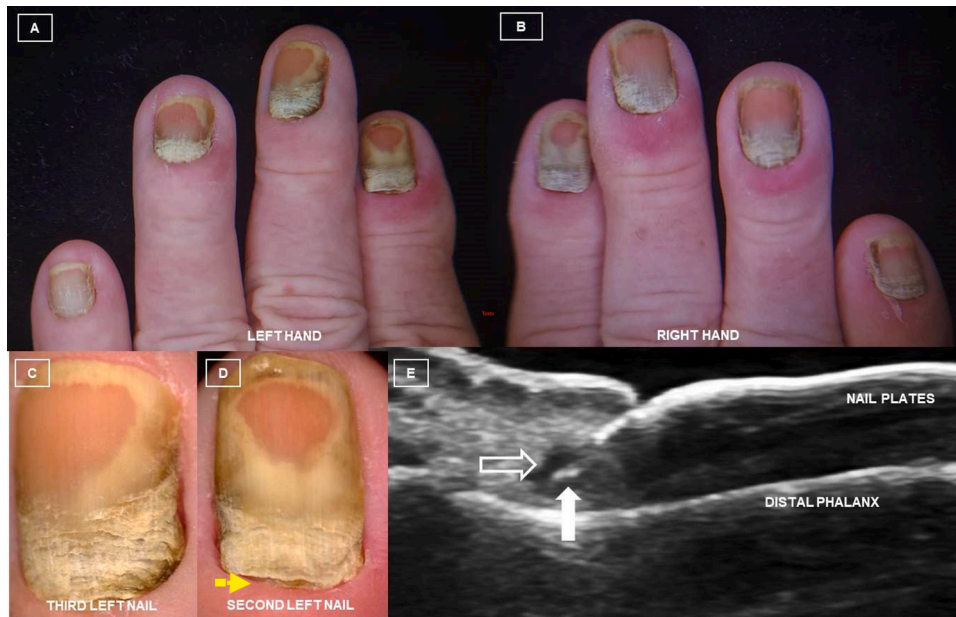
Parts A-D. Clinical and dermoscopic images. Part E. Nail unit ultrasound picture.
